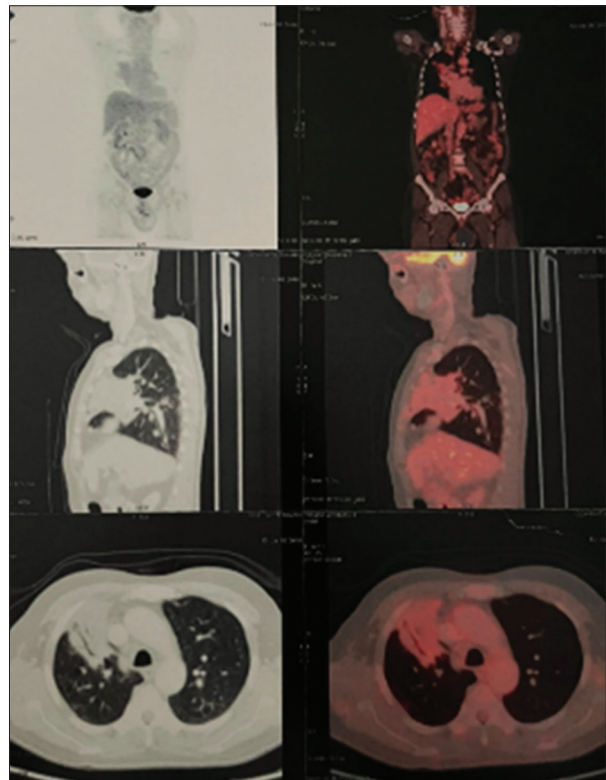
Post 2# Interim positron emission tomography-computed tomography - shows significant response (SUV_{max} 3.98 from initial 17.23). Non-fluorodeoxyglucose avid pretracheal and subcarinal nodes, the largest measuring 1.2 cm
